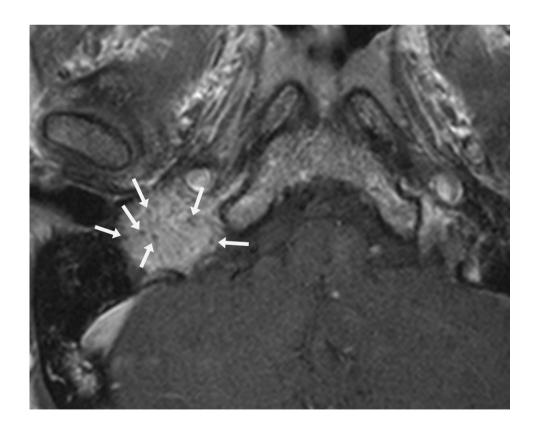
Glomus jugulare paraganglioma on MRI. Axial contrast-enhanced T1-weighted image through the right skull base demonstrates an avidly enhancing mass with internal flow voids (arrows) centered at the jugular foramen, giving the lesion a "salt-and-pepper" appearance that is characteristic of a paraganglioma
